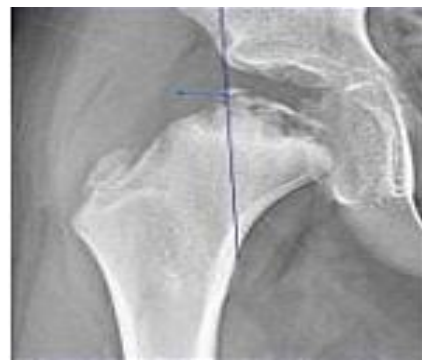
Frog leg radiograph of a boy with perthes disease in the left hip showing "Finger nail hit" sign
